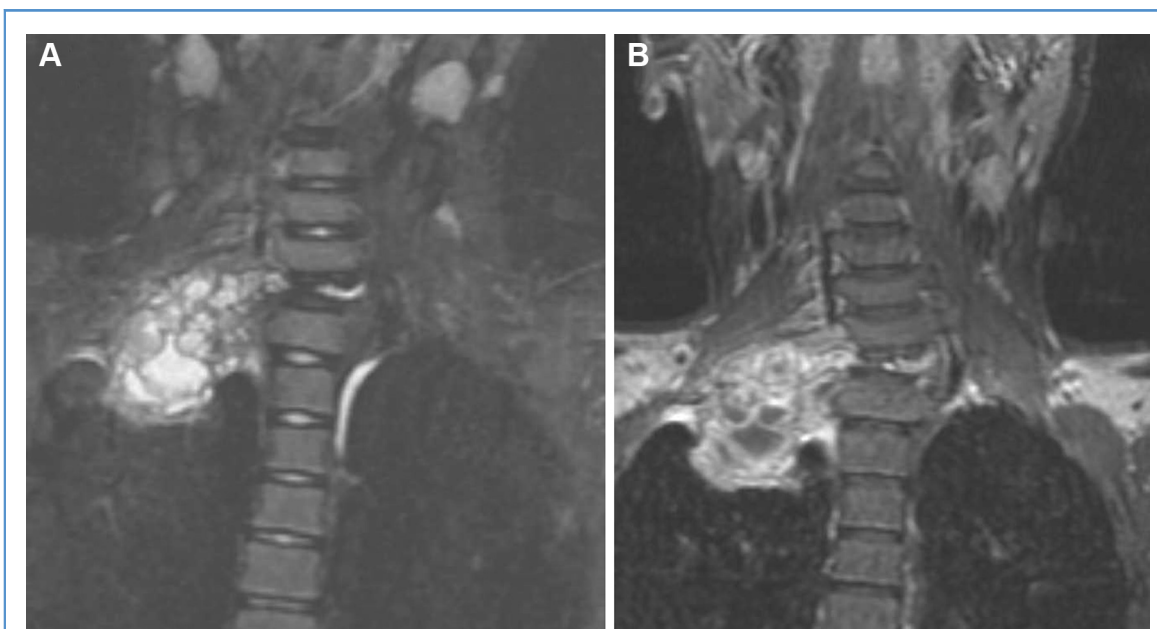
Pretreatment coronal short-TI inversion recovery magnetic resonance image (MRI) (A) and contrast-enhanced coronal T1W MRI (B) showing large predominantly solid mass
